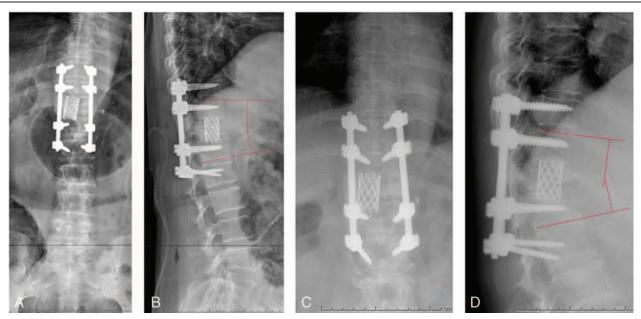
A and B are X-ray in 1 week after operation; C and D are X-ray in 1 year after operation.
